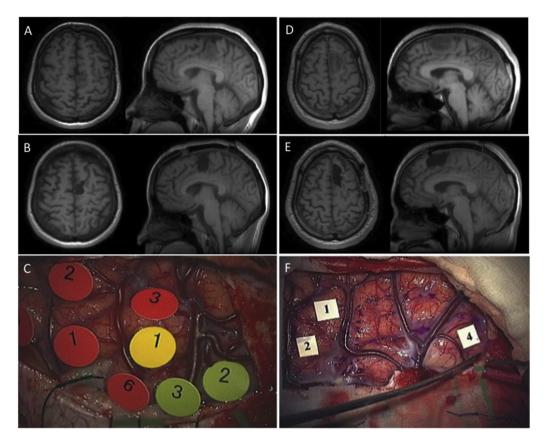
Results of imaging and functional mapping. Case 1 (left). Preoperative T1-weighted MRI sagittal image showing a hypointense lesion in the left SMA (A). Postoperative T1-weighted MRI sagittal image showing a resection cavity located in the SMA, which did not extend to the cingulate gyrus below (B). Intraoperative functional mapping results (C); Tags 1 (left) and 2 (upper left) indicate speech arrest and a negative motor response by stimulation during simultaneous movement and object-naming task. Tag 3 (lower) indicates an inability to answer with any *Kana* in the 2-back task. Tag 6 indicates incorrect responses with different *Kana* in the 2-back task. Case 2 (right). Preoperative T1-weighted MRI showing a hypointense lesion in the left SMA (D). Postoperative T1-weighted MRI showing a resection cavity located in the SMA, which did not extend to the cingulate gyrus below (E). Intraoperative functional mapping results (F); Tags 1 and 2 indicate speech arrest and a negative motor response by stimulation during simultaneous movement and object-naming task. Tag 4 indicates incorrect answers with different *Kana* in the 2-back task.
